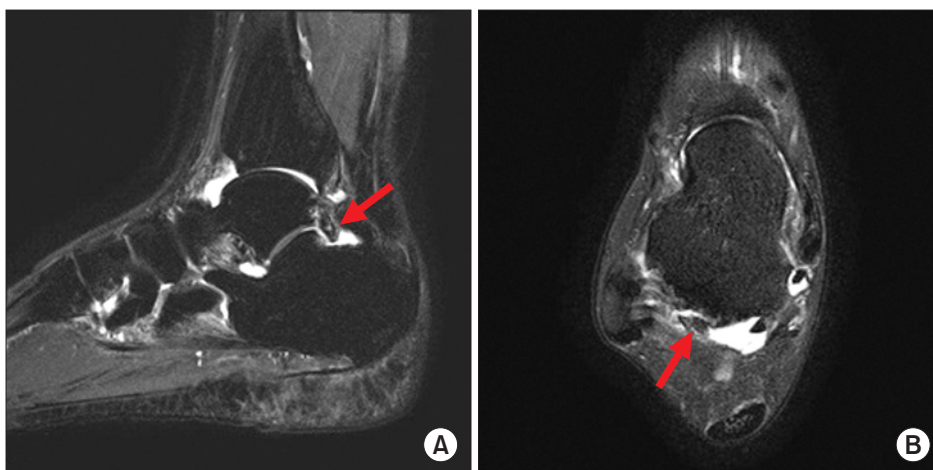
Magnetic resonance images showing prominent osteophyte at posterior aspect of the talus at sagittal view (A; arrow) and at axial view (B; arrow).
